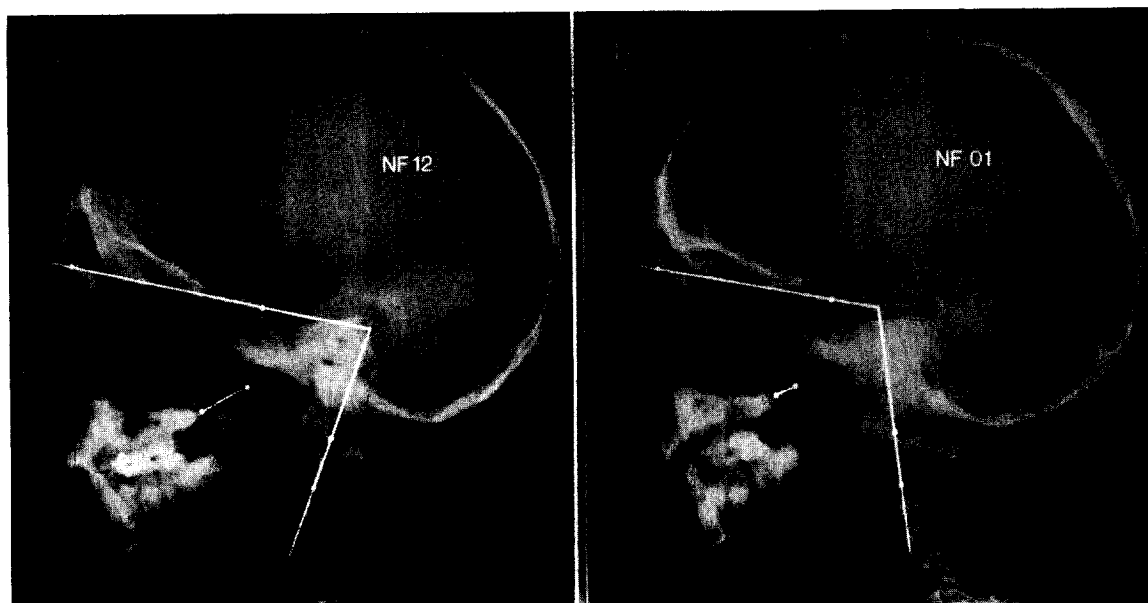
Respiratory obstruction and craniocervical angulation as judged from cephalometric radiographs of subjects recorded in the natural head position. A, Subject NF 12 showing good sagittal extent of nasopharyngeal passage (pm-ad 2 = 19.0 mm) and small craniocervical angle (NSL/OPT = 81.4°). B, Subject NF 01 showing relatively narrow sagittal extent of nasopharyngeal passage (pm-ad 2 = 7.2 mm) and large craniocervical angle (NSL/OPT = 107.3°).
